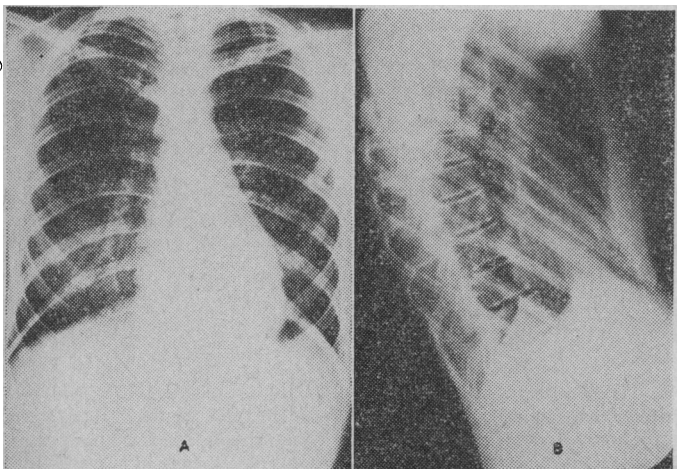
Chest radiographs taken four months after removal of bandages, showing regression of sternal depression.
